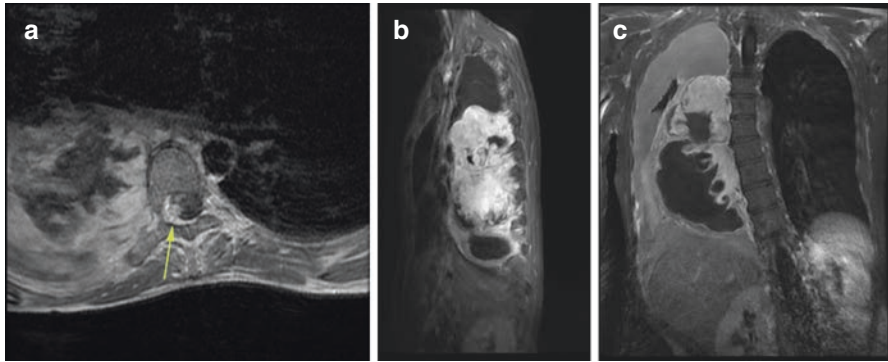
T1-weighted MRI with contrast. (a) Axial series showing an extradural enhancing mass along the right T6 root. (b, c) Sagittal and coronal series showing the giant extraforaminal, intra-thoracic malignant nerve sheath tumor
